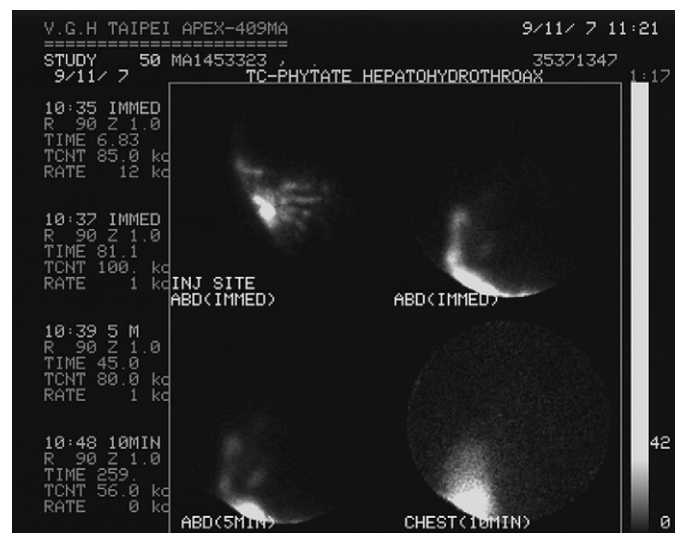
Tc-99m phytate hepatohydrothorax scintigraphy revealing that the isotope injected in the abdomen migrated to the chest (arrowhead) 10 minutes later.
